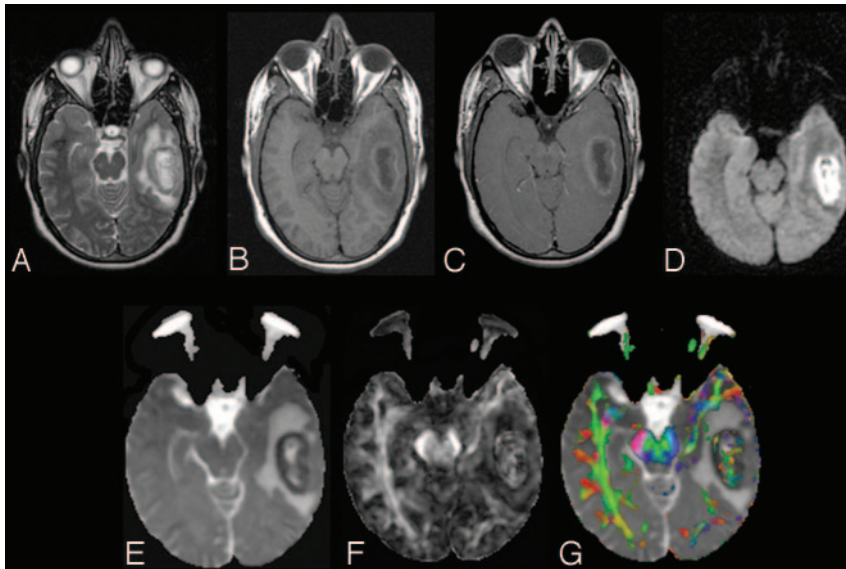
A 25-year-old male patient presenting with pyogenic brain abscess with a heterogeneously hyperintense lesion in the left temporal lobe. *A*, Axial T2-weighted image shows a hyperintense lesion with a hypointense wall. *B*, The lesion appears hypointense on the axial T1-weighted image with an isointense wall. *C*, On the postcontrast T1-weighted image, the lesion shows ring enhancement. *D*, The lesion appears heterogeneously hyperintense on the DWI in the cavity that appears heterogeneously hypointense on the MD map (*E*). The FA (*F*) and red-green-blue color-modulated FA map fused with MD map (*G*) show that high FA in the abscess cavity is similar to what is observed in the contralateral inferior longitudinal fasciculus and midbrain.
